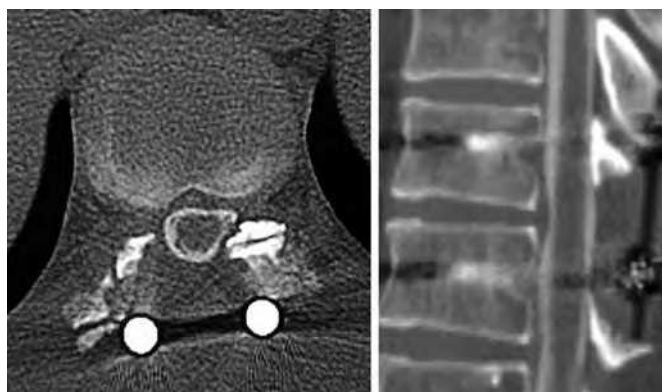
Postoperative myelopathy computed tomography in a representative case.
